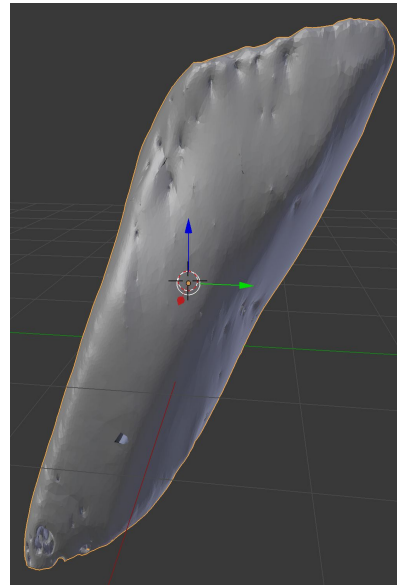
The CT reconstructed upper respiratory tract once smoothed with Blender's texturing tools.
